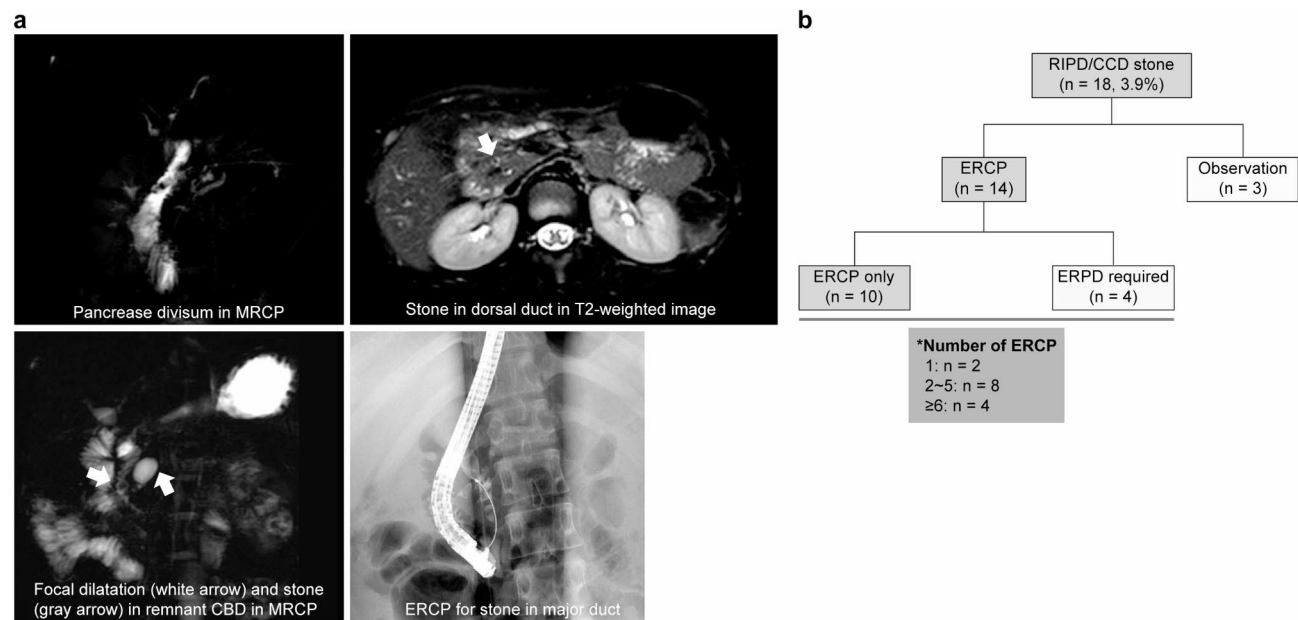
Choledocholithiasis in RIPD/CCD. (a) Each image shows the following: pancreas divisum as seen on the 2D T2 thick-slab turbo spin echo image (top left), stone in the duct of Santorini as seen on the axial fat-saturated T2 weighted image (arrow in top right), stone in the RIPD/CCD (arrow) as seen on the 2D T2 thick-slab turbo spin echo image MR image (bottom left), and removal of a stone from the duct of Wirsung through ERCP (bottom right). (b) In 18 patients, stones were identified in the RIPD/CCD. The observation was conducted in three asymptomatic patients, whereas in patients with larger stones or accompanying pancreatitis, stones were removed through ERCP. Four patients required ERPD due to severe stenosis of the pancreatic duct, and except for two patients, all required ERCP procedures more than twice. *RIPD: remnant intrapancreatic common bile duct; CCD: common channel duct; MR: magnetic resonance; ERCP: endoscopic retrograde cholangiopancreatography; ERPD: endoscopic retrograde pancreatic drainage.
